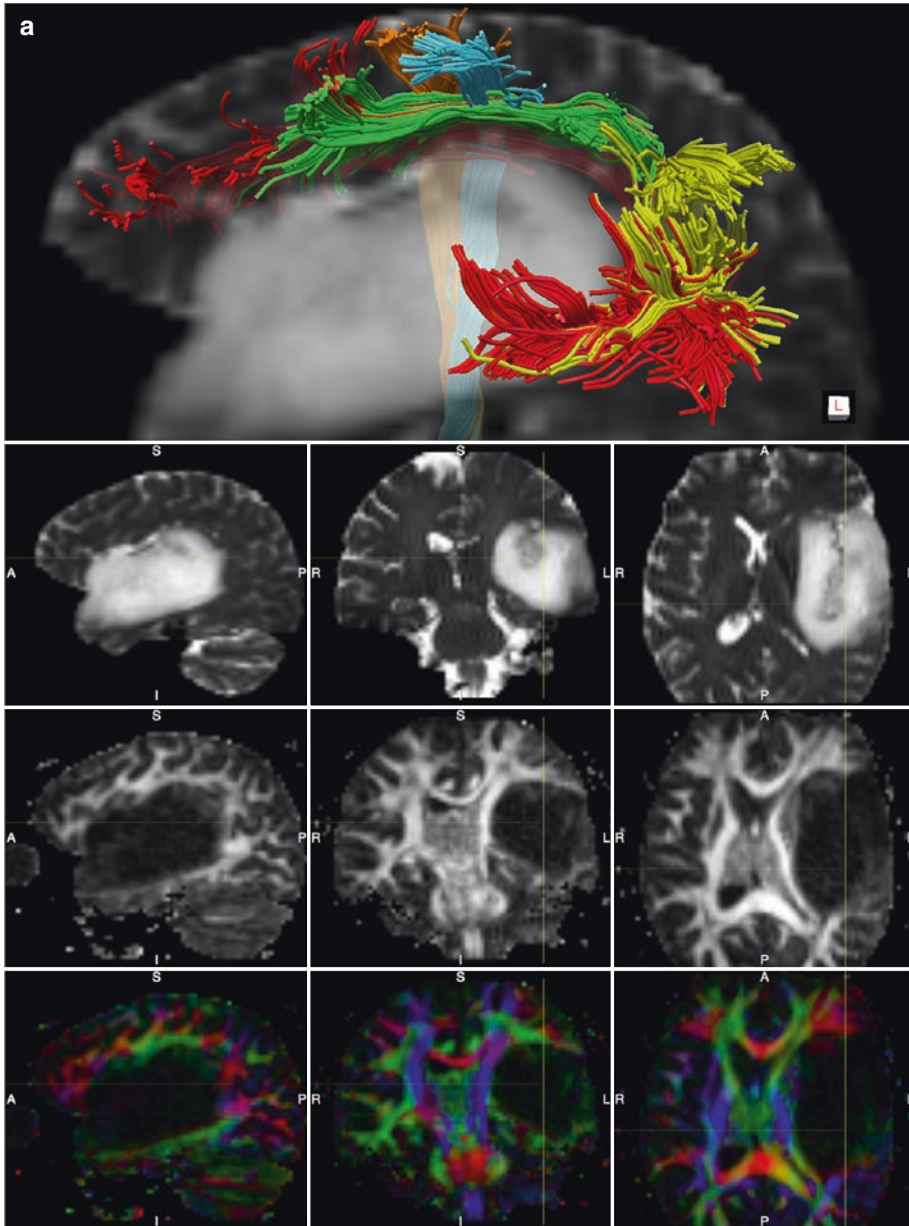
(a) Thirty-six years-old male with astrocytoma WHO-II. The three segments of the left AF (direct segment in red, posterior segment in yellow, and SLF-III in green) and two components of the CST projecting respectively to M1 (yellow) and S1 (cyan) in the area of the face/mouth are displayed over a sagittal T2-weighted MRI (upper row). Note in sagittal, coronal, and axial T2-weighted MRI (second row), FA maps (third row) and DEC maps (bottom row) that the large mass is infiltrating the left insula and the whole temporal lobe and it is displacing the CST medially and the AF dorsally. Presurgical tractography was useful to show that eloquent fascicles (AF and CST) were outside of the mass, thus a complete
